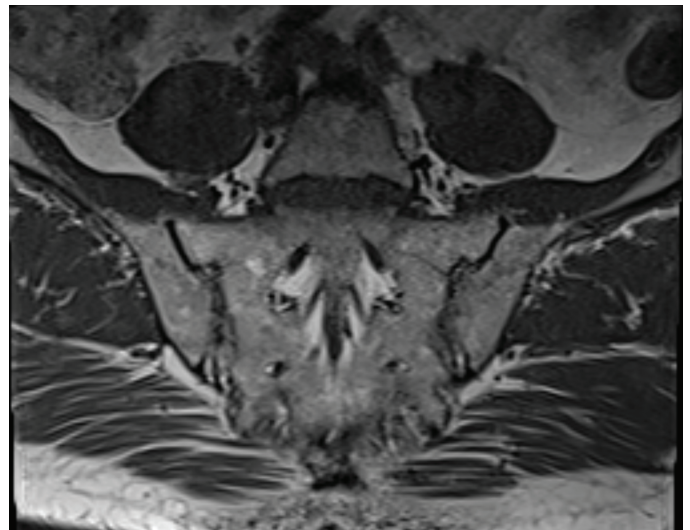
Bridging ossification is seen at the anterior and superior aspects of the sacroiliac joints in this MRI
